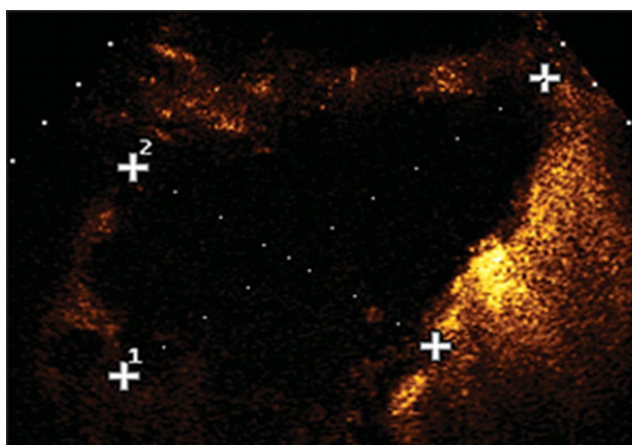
Right intercostal contrast-enhanced sonogram showing a 10 cm × 7 cm ablation area produced after two insertions of a 14-gauge internally-cooled, minichoked MW antenna using a power output of 90 W for a total ablation time of 20 min
